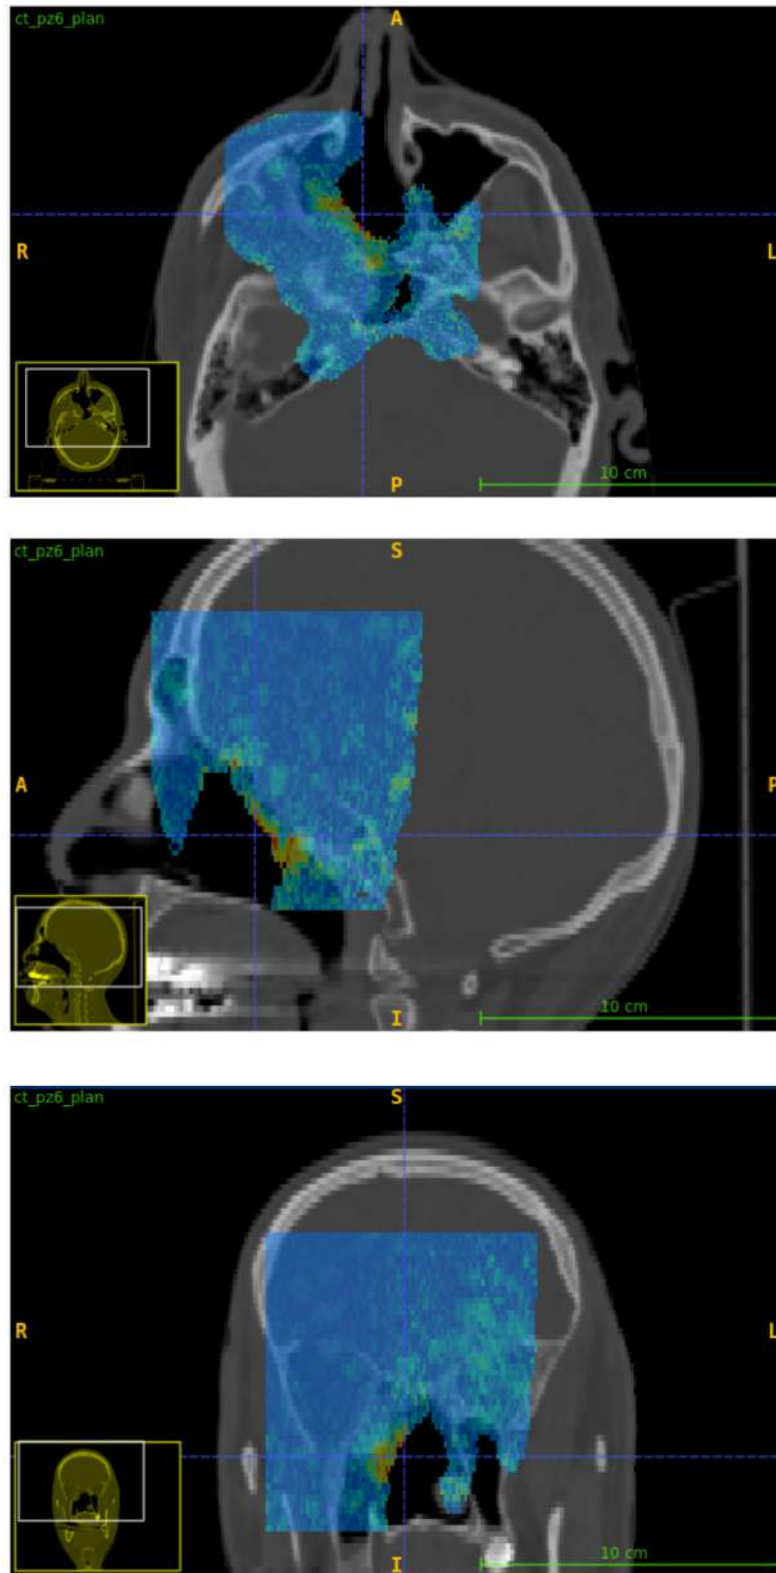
Gamma mode map for  $DD = 45\%$ ,  $DTA = 4$  mm,  $DTH = 0.5\%$  in axial, sagittal and coronal views (from top to bottom), overlaid on the planning CT.
